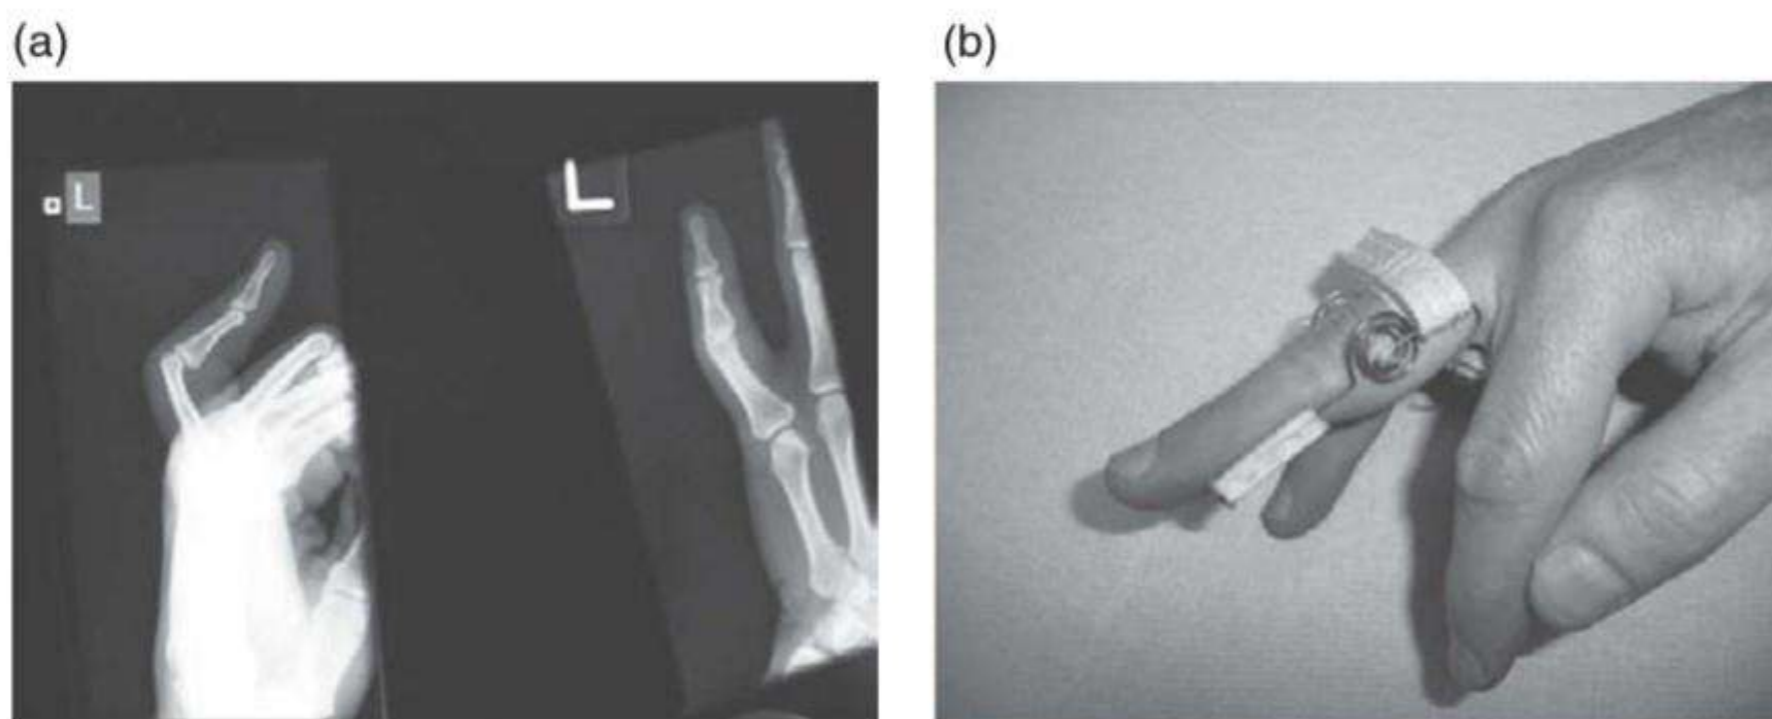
Anteroposterior (AP) and lateral radiographs of a little finger. 11.10b Picture of a splint used to manage a Boutonnière deformity.
